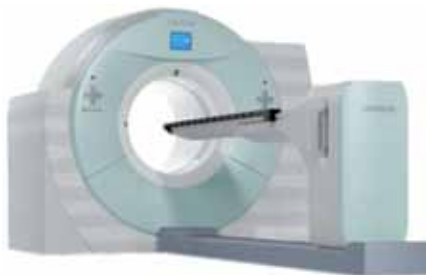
Siemens Biograph mCT PET/CT scanner.
